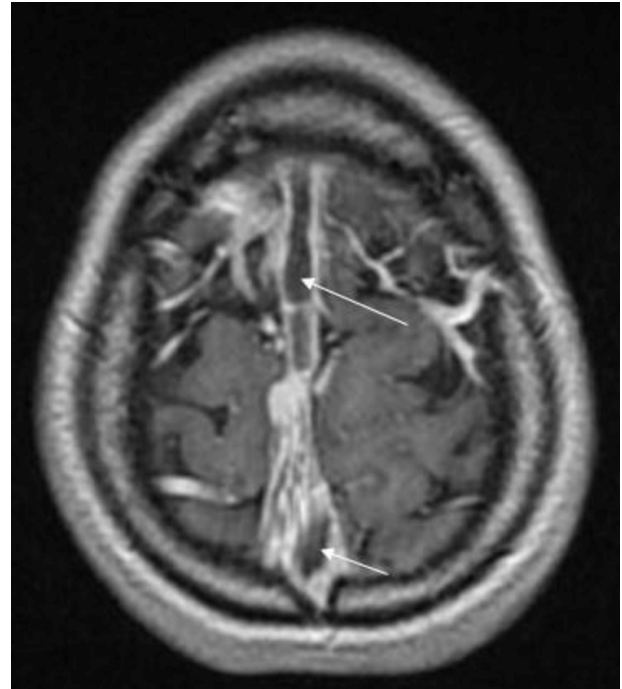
Axial contrast-enhanced T1 magnetic resonance imaging scan through the vertex of the head showing non-occlusive thrombus as a filling defect (arrows) within the superior sagittal sinus.
